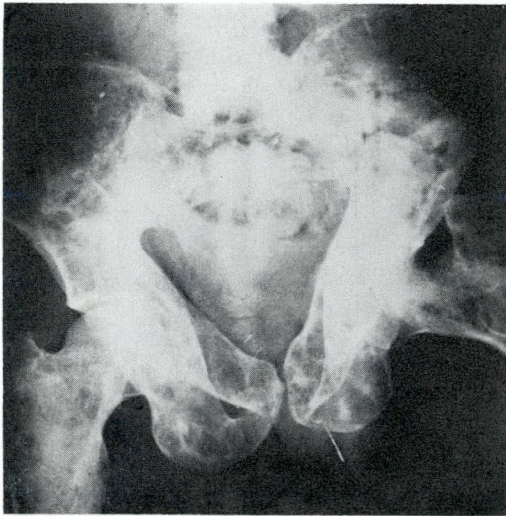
Radiograph of the pelvis showing multiple osteolytic areas in the pelvis and upper part of the femur. Distortion of the pelvis is also evident.
